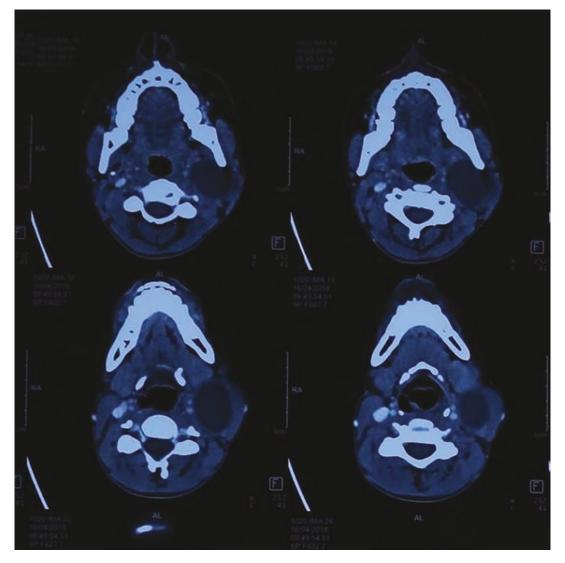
Contrast-enhanced CT scan axial images showing a well-defined hypodense lesion in the left side of the neck
